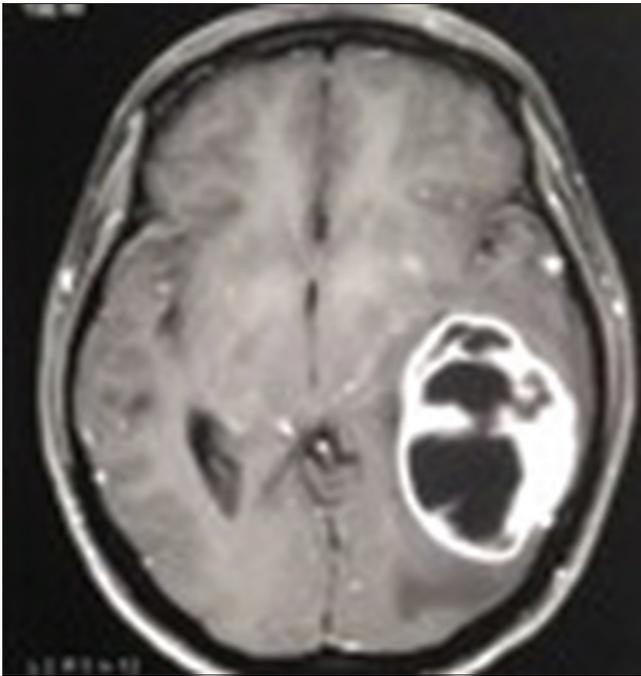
Magnetic resonance imaging-brain – glioblastoma multiforme tumor in posterior temporal lobe before excision
